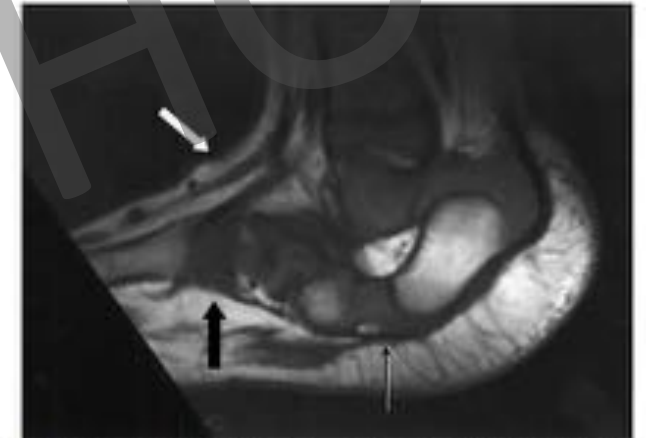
Sagittal view of the foot and ankle (T1-weighted image): calcaneocuboid joint subluxation (thin black arrow); bowstring of the extensor retinaculum (white arrow); distal cavus (thick black arrow).
